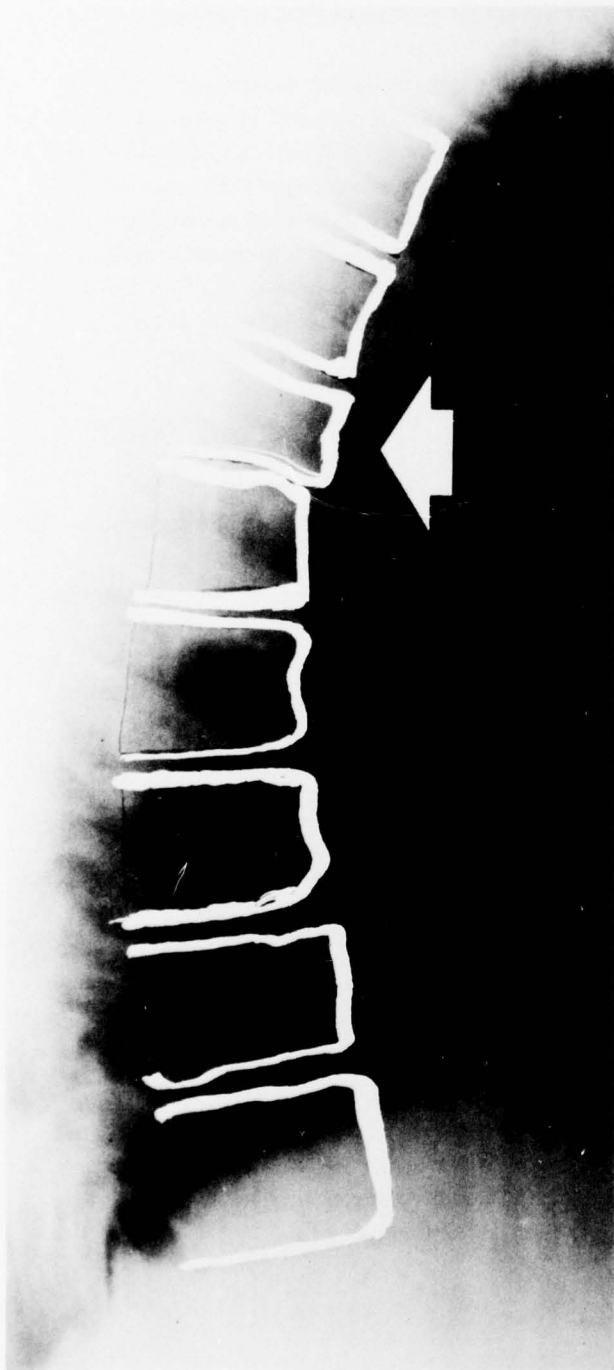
Lateral Radiograph Shows Combined Anterior Wedge Compression Fracture and Disruption of Posterior Vertebral Column
